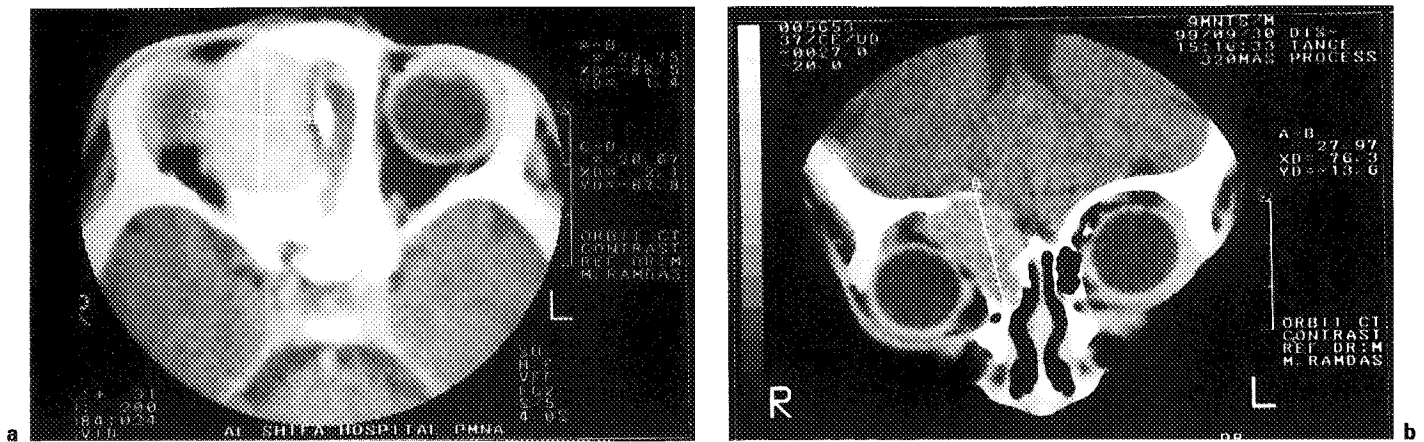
CT scan with contrast administration; axial (a) and coronal view (b) showing well-defined mildly enhancing extraconal lesion in the superomedial compartment of the orbit with erosion of the superomedial wall.
